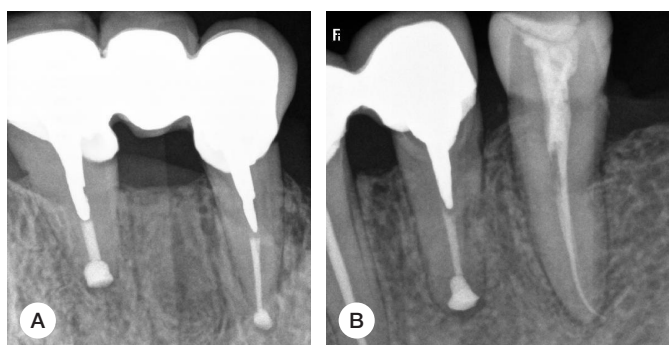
(A, B). Bitewing radiographs of the replanted teeth 1.1–1.3 and 3.4 of the same patient
